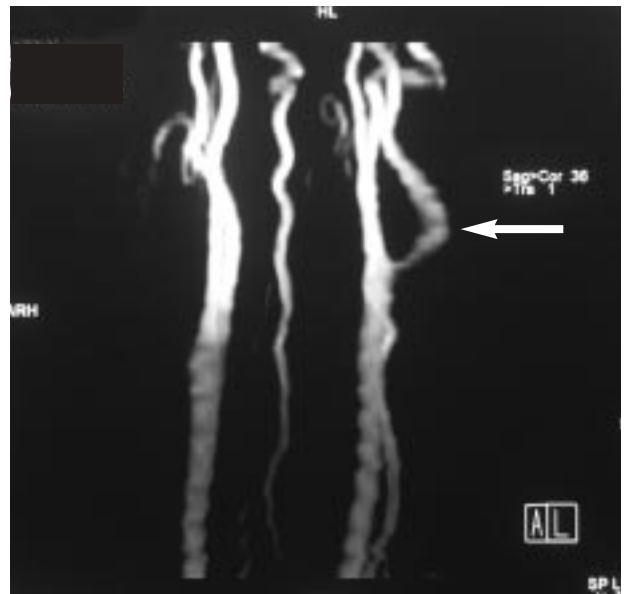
MRI sagittal section showing left-carotid dissection (arrow).
